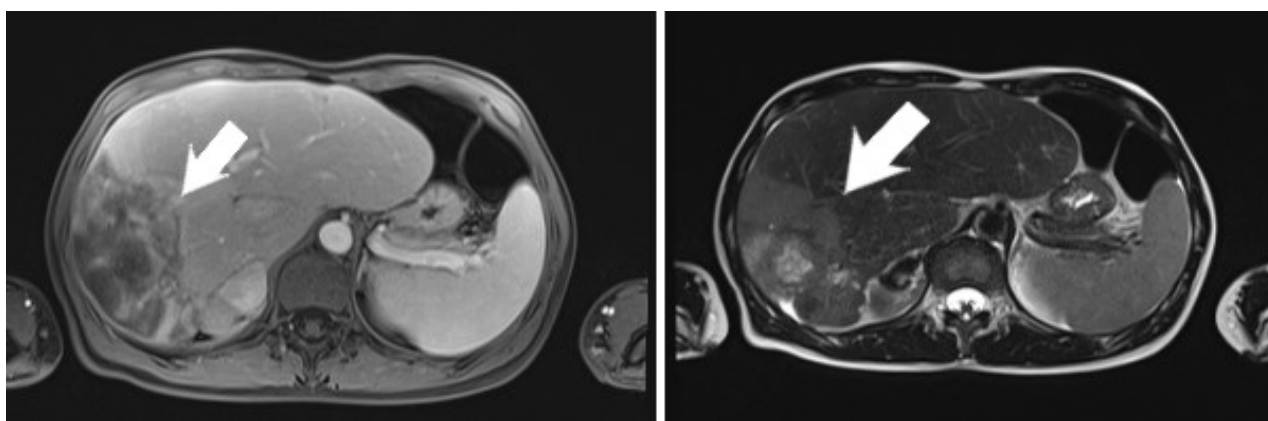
Abdominal magnetic resonance images. Left image: T1; Right image: T2; White arrow: Infiltrative lesion invading nearly the entire right lobe, heterogeneous signal intensity and central necrosis.
